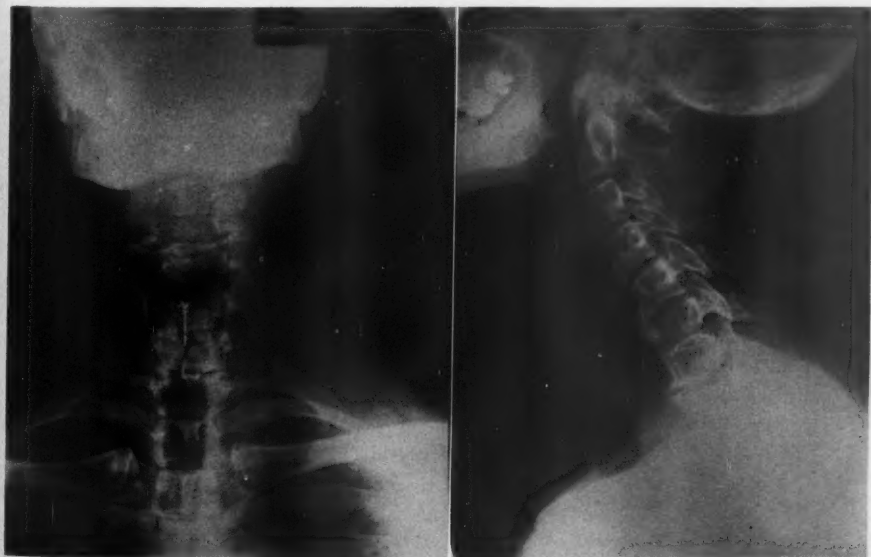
X-rays of extensive osteoarthritic changes involving cervical spine. Day following injury
